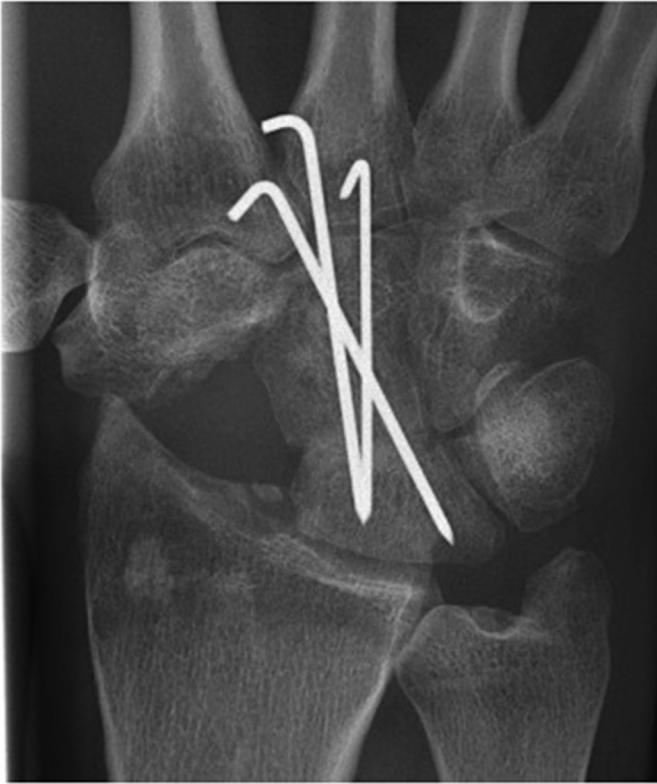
Radiograph of a lunocapitate arthrodesis.
